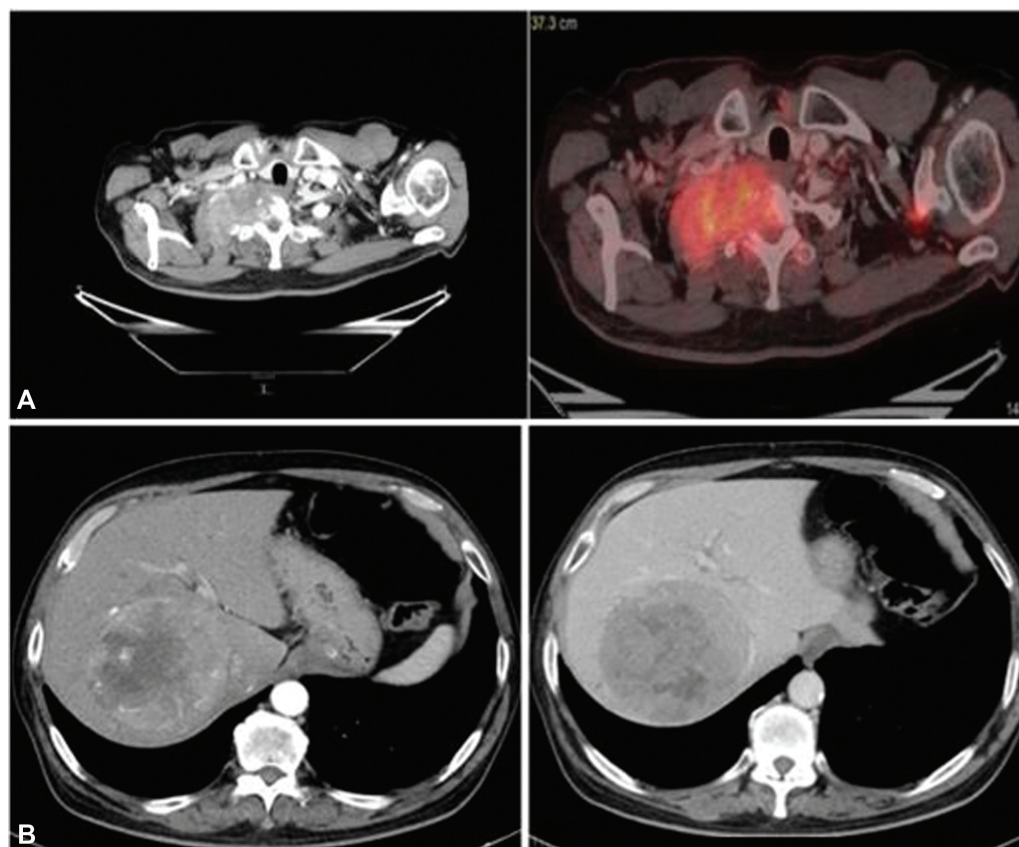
(A) Positron emission tomography computed tomography (CT) scan shows a right upper lobe mass lesion of size 6.1 × 4.8 cm with the erosion of C7 and D1 vertebra. (B) Triple phase CT: of the abdomen showing a 9 cm lesion in the segment VI & VII suggestive of HCC (Arterial and portal phase).
